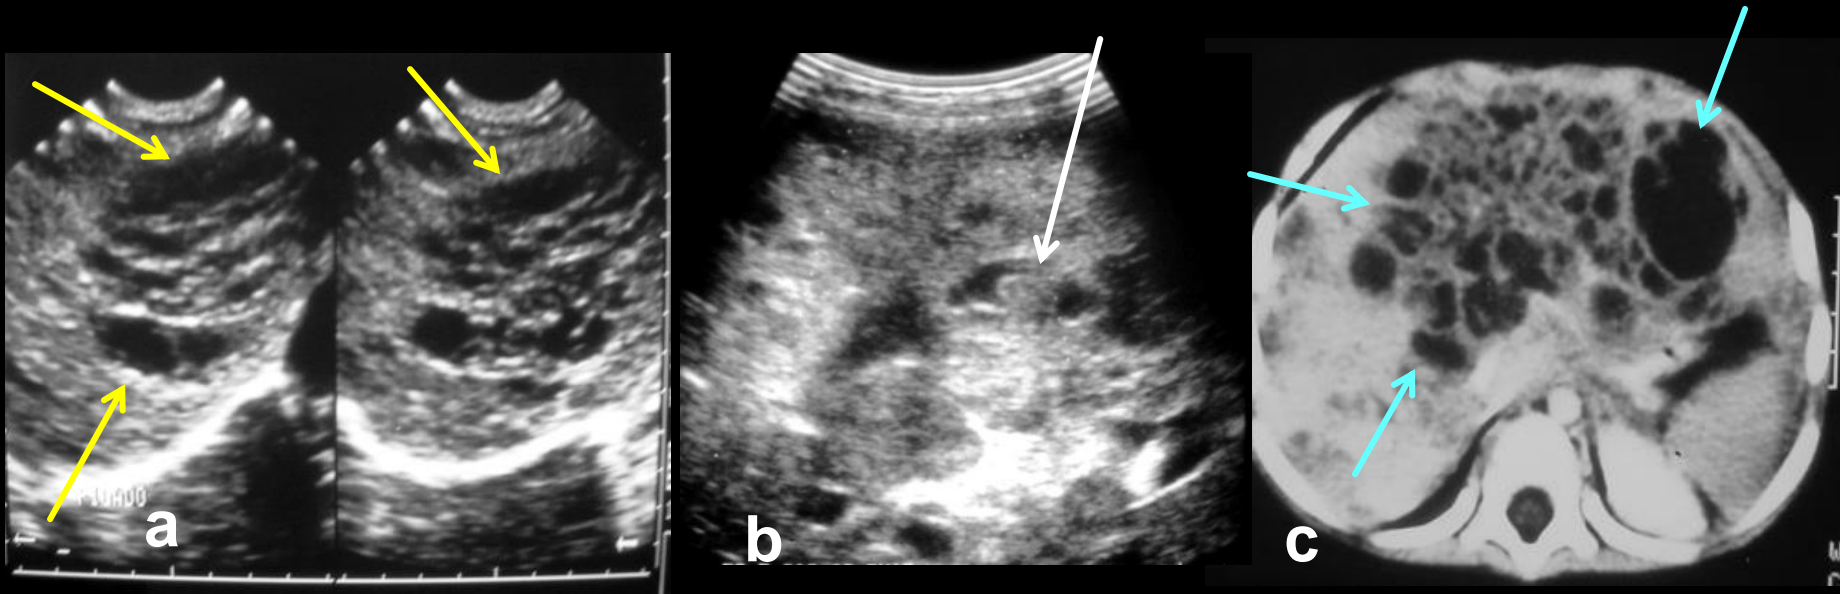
Transverse sonography (a,b) of a 5-year-old boy admitted with abdominal pain, fever and diarrhea, showed multiple hypoechoic focal lesions of hepatic abscesses (yellow arrows). Septic thrombus in a portal vein branch(white arrow). Transverse CT image of the same patient (c) demonstrates multiple low attenuation liver lesions corresponding to pyogenic hepatic abscesses (blue arrows). Bacterial enteric infections in children may be the source of suppurative thrombophlebitis of the superior mesenteric vein and hepatic abscesses.
